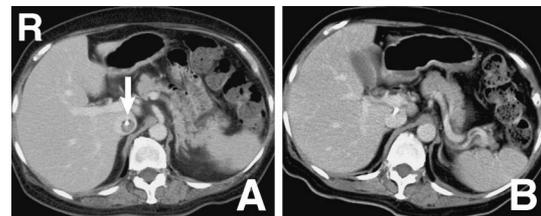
Computed tomography scans with contrast medium of the abdomen before treatment with urokinase (A) showing catheter-related thrombosis (arrow) of the inferior vena cava, and after treatment (B) showing thrombolysis.
